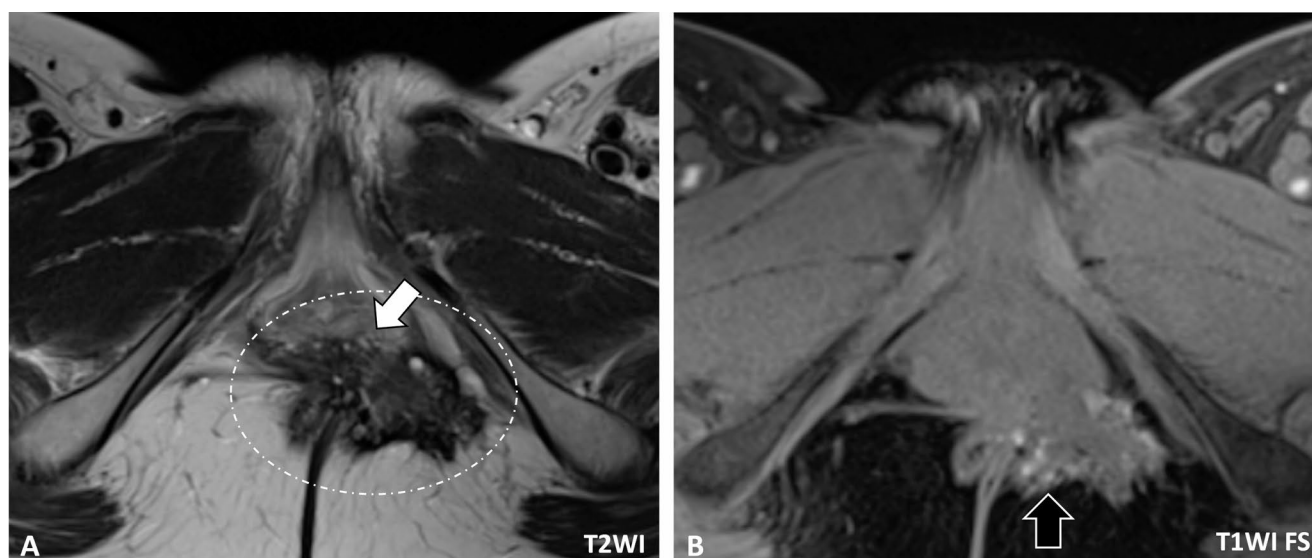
44-year-old woman presenting with perianal pain and intermittent bleeding. Pelvic MRI: axial T2WI (A) and pre-contrast axial T1WI FS (B). Images demonstrate a spiculated, predominantly T2WI-hypointense lesion within the left ischioanal fossa, at the site of a prior
